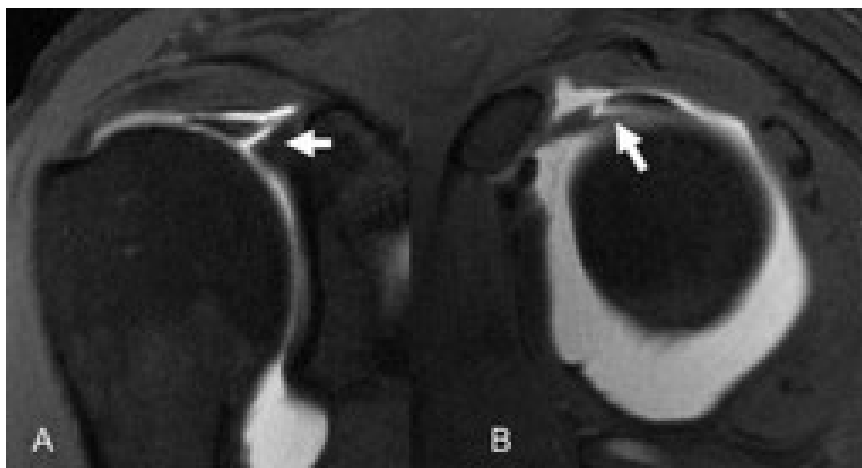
A 32-year-old man with SLAP lesion type II. A) Coronal T1-weighted fat-suppressed MR image shows a tear of the anterosuperior glenoid labrum (arrow); B) sagittal T1-weighted fat-suppressed MRA image demonstrates involvement of the biceps labral complex (arrow).
